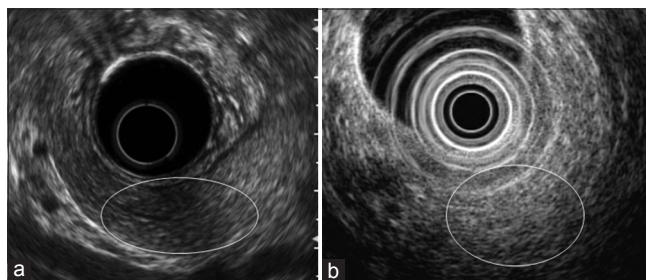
Normal pancreatic parenchyma on endoscopic ultrasonography. Homogeneous and fine-reticular pattern is visible in both images (a and b, circle) of parenchyma without dilated ducts (a, circle)
